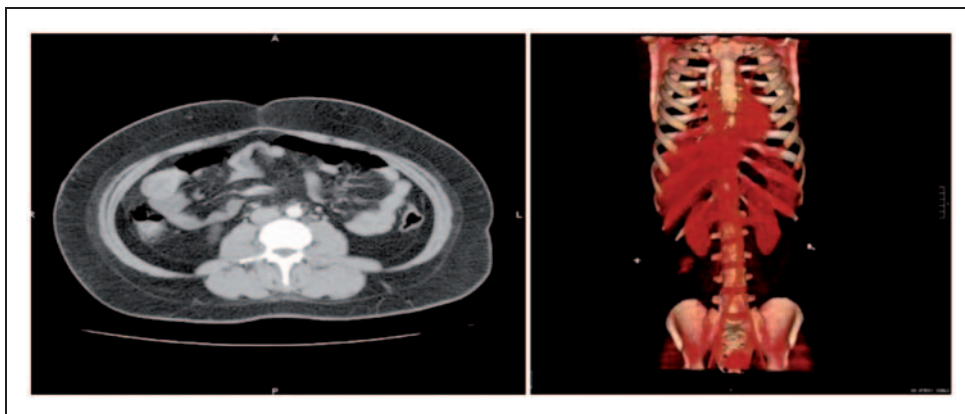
Computed Tomography cross sections showing a mass on the right side of the abdomen. CT Angiogram outlines a vascular mass in the jejunum, consistent with the appearance of a polypoidal tumour.
